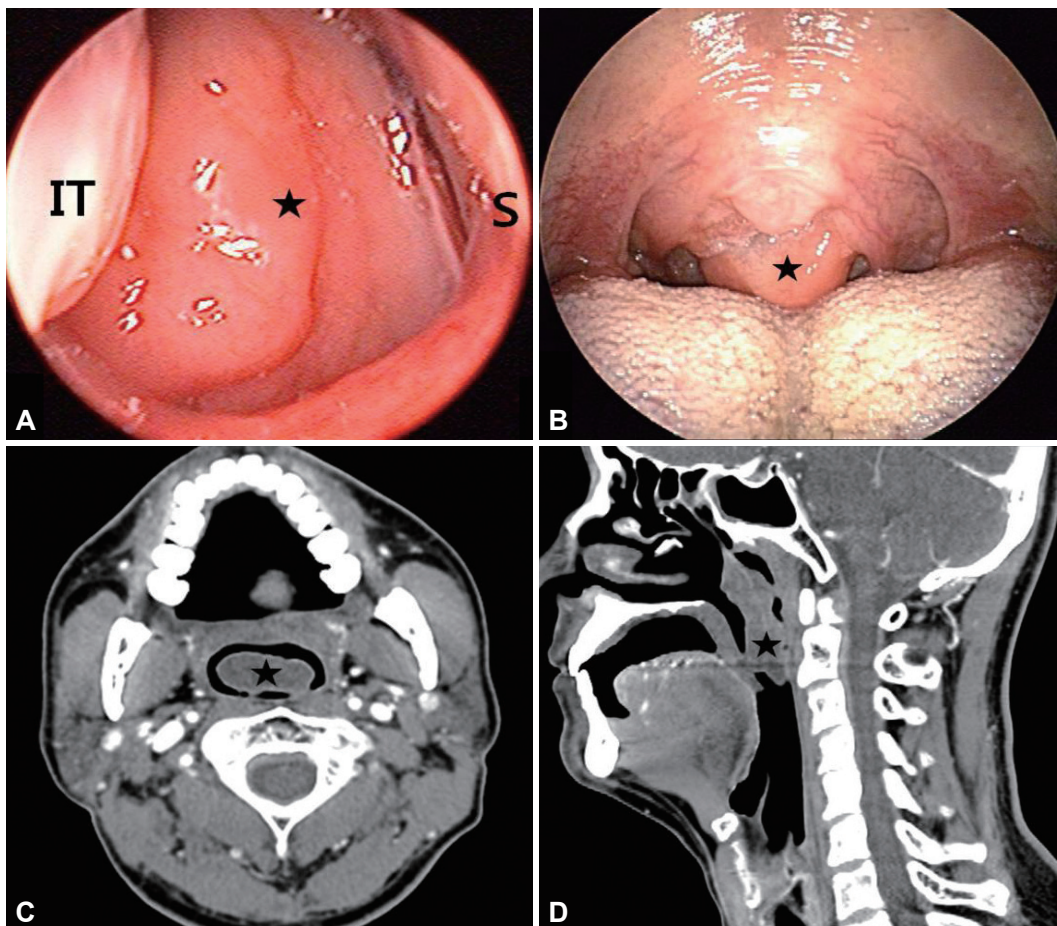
Nasal mass presenting as mild obstructive sleep apnea syndrome (Case 1). Right posterior nasal (A) and oral (B) endoscopic findings and axial (C) and sagittal (D) views of computed tomography showed a large mass occupying the naso and oropharynx. IT: inferior turbinate, S: septum, black asterisk (★): nasal mass.
